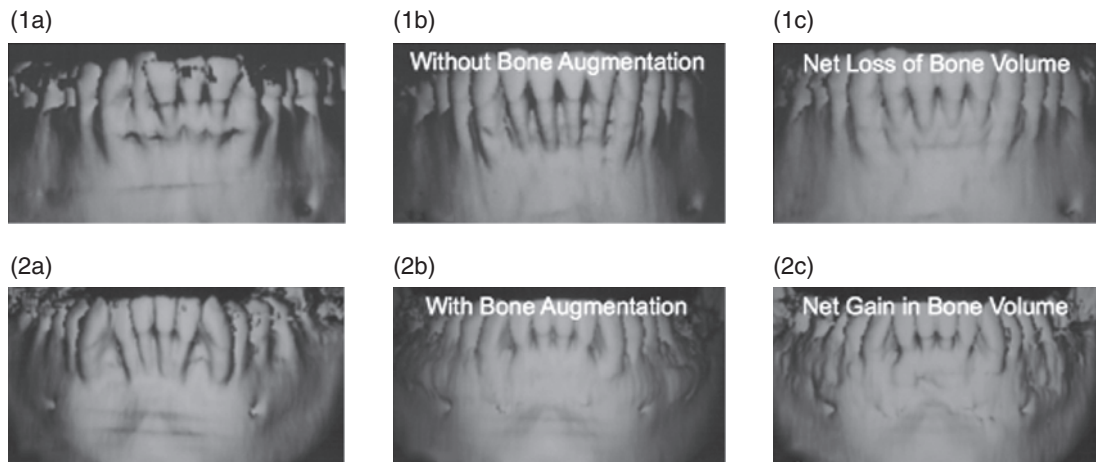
(1a) Comparison of SAD with (PAOO/AOO) and without a bone graft demonstrating the necessity for grafting when insufficient bony support is evident in adults. The figure shows the pre-treatment high-resolution computerized tomography (CT) scan (accurate to 0.2 mm) of the lower arch of a female, age 39, prior to having circumscribing corticotomy cuts performed both labially and lingually around the six lower anterior teeth. Note the arch length deficiency (overlap crowding), the pronounced crestal glabella, and the distance between the crest of the alveolus and the corresponding cemento-enamel junctions (CEJs). Clinically, the circumscribing corticotomy cuts resulted in the appearance of outlined “blocks of bone” connected by medullary bone. The total treatment time for this case was 4 months and 2 weeks with eight adjustments appointments. (1b) At 1 month retention the integrity of the outlined “blocks” of bone appears to have been completely lost and the layer of bone over the labial root surfaces appears to have vanished. In reality, this layer of bone has undergone demineralization as the result of a normal osteopenic state (RAP); the soft tissue matrix of the bone remains but is not visible radiographically. This is why radiographic assessments of expansion cases before 3–4 years in retention, while interesting in the short term, are premature for final policy conclusions. This demineralized matrix was carried into position with the root surfaces (bone matrix transportation). (1c) This shows the high-resolution CT scan at 2 years and 8 months retention. Note that the layer of bone over the root surfaces has only partially reappeared due to the remineralization of the soft tissue matrix.
